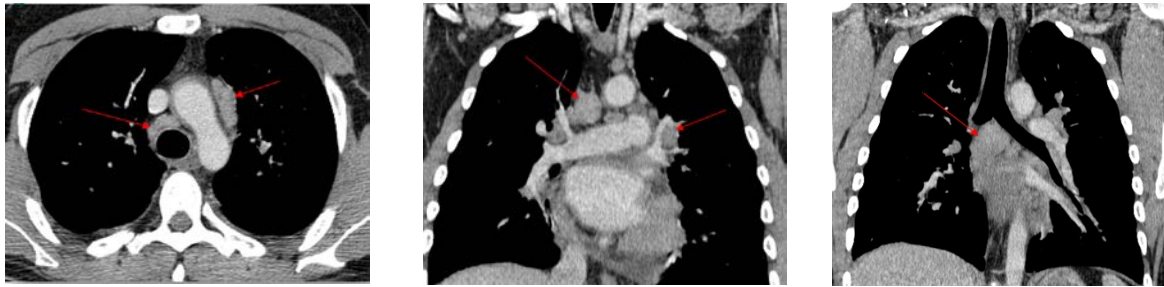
Computed tomography scan of the chest: enlarged lymph nodes in mediastinum (red arrows).
